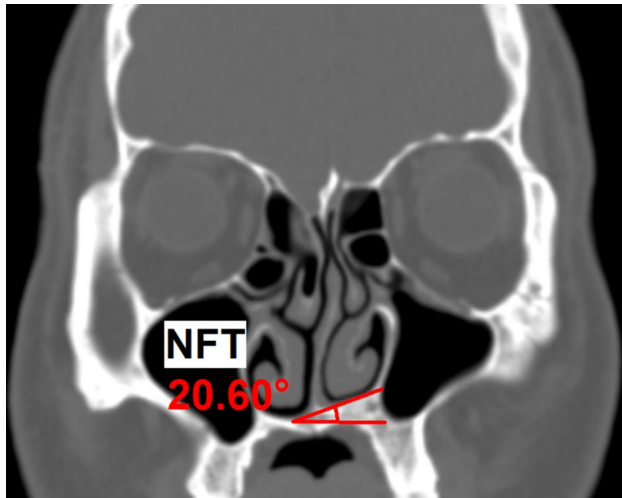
Measurement of the Nasal Floor Tilting (NFT). On a coronal image of the OMU CT image, the most inferior point of the bony nasal floor in each nasal cavity were marked. Then, on either side, a horizontal line starting from the marked point was drawn. Finally, a line connecting two marked points on each side was made. The degree of angle between two lines was measured and represented as the 'NFT angle'. In addition, the side of the higher nasal floor was investigated
